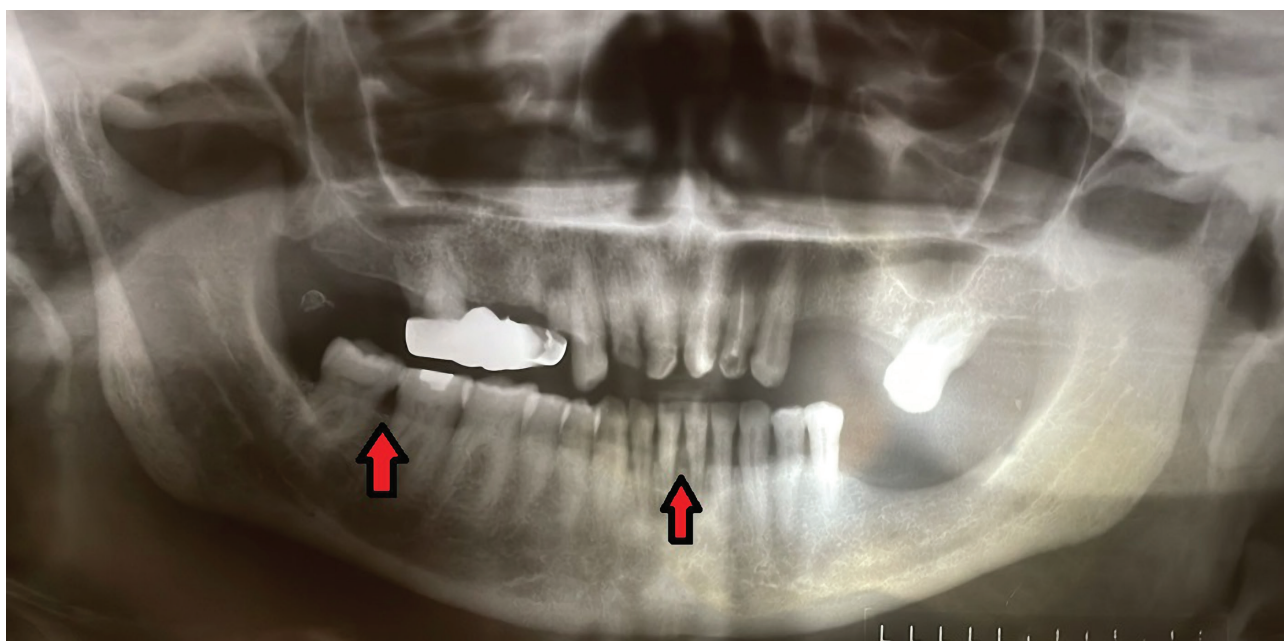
OPG x-ray of a patient with DM and CKD. Bone resorptions are marked with arrows.
